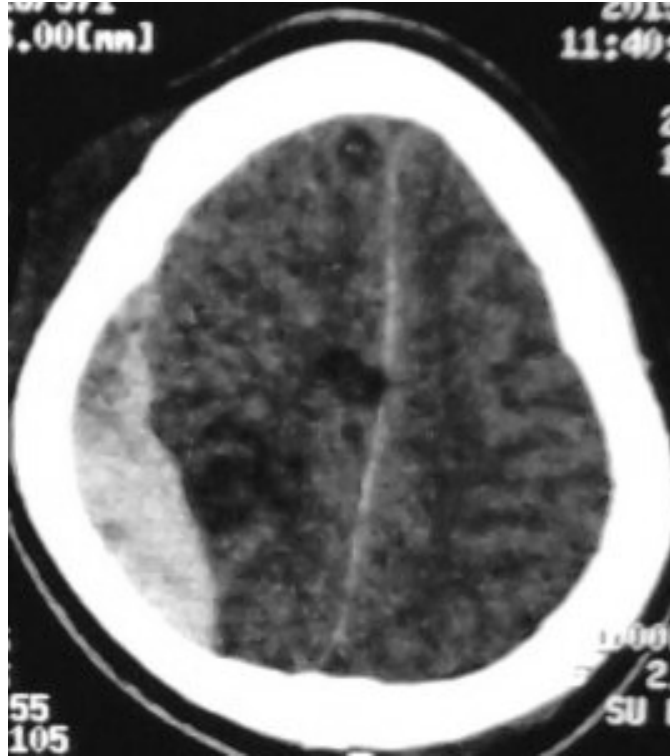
Brain CT performed for convulsive seizures in a 47-year-old patient with a history of trauma. Right frontal extradural hematoma.
